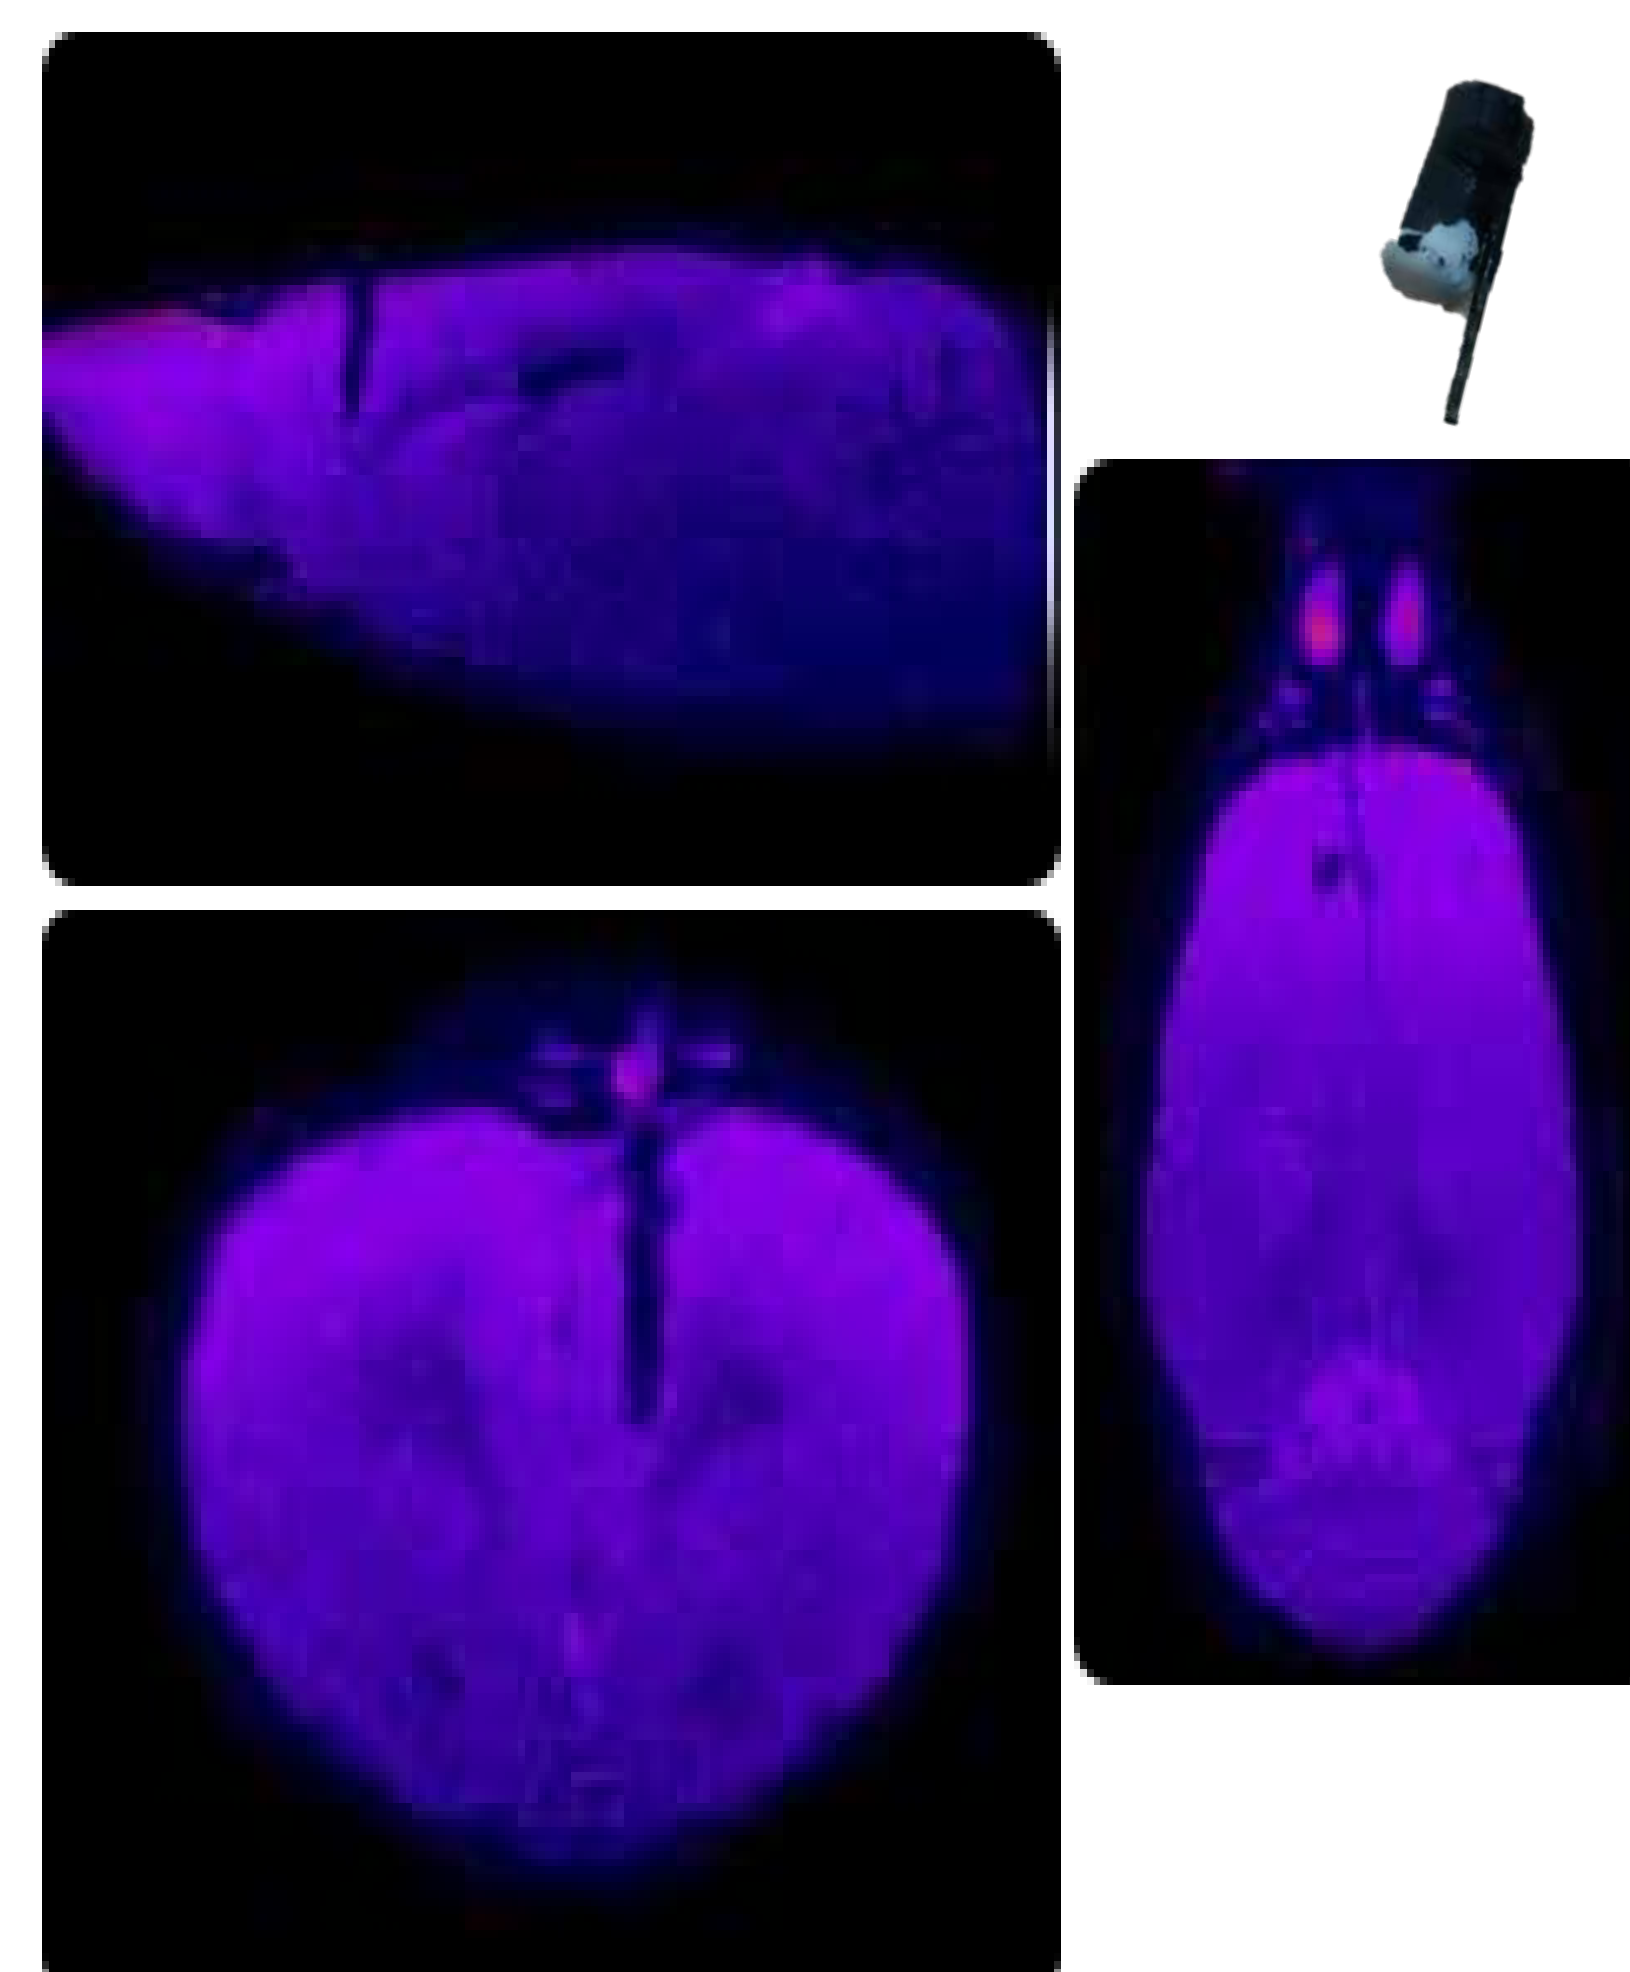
Implantation of MRI compatible carbon electrodes in the PL
